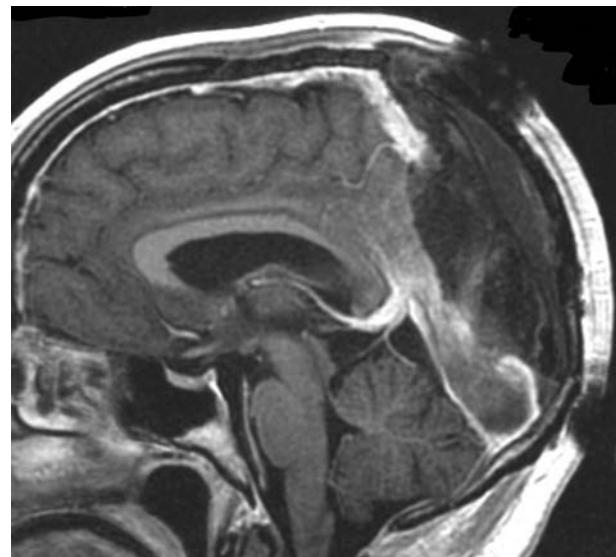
Second surgery postoperative sagittal T1-weighted magnetic resonance imaging showing the resection of the occluded sinus.
